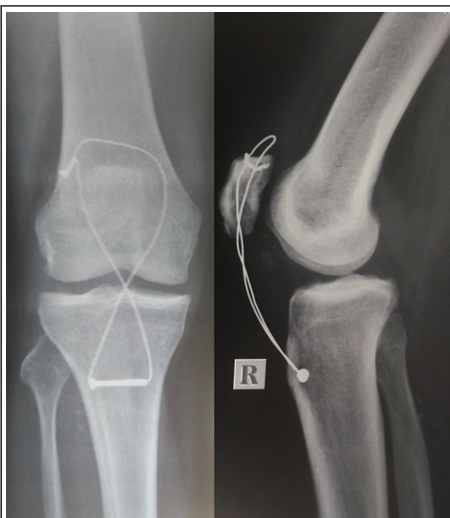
Post-operative Antero-posterior and Lateral plain X-Rays Right Knee
